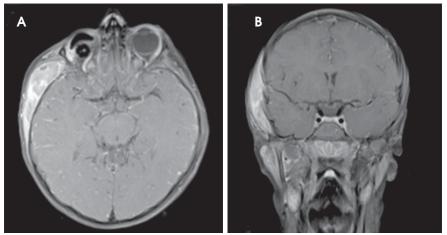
MRI demonstrating a well-defined solid enhancing mass within the right infratemporal fossa involving the right zygomatic arch, right skull base, and mandibular ramus. Note the enlarged right parotid and right upper cervical chain lymph nodes.
